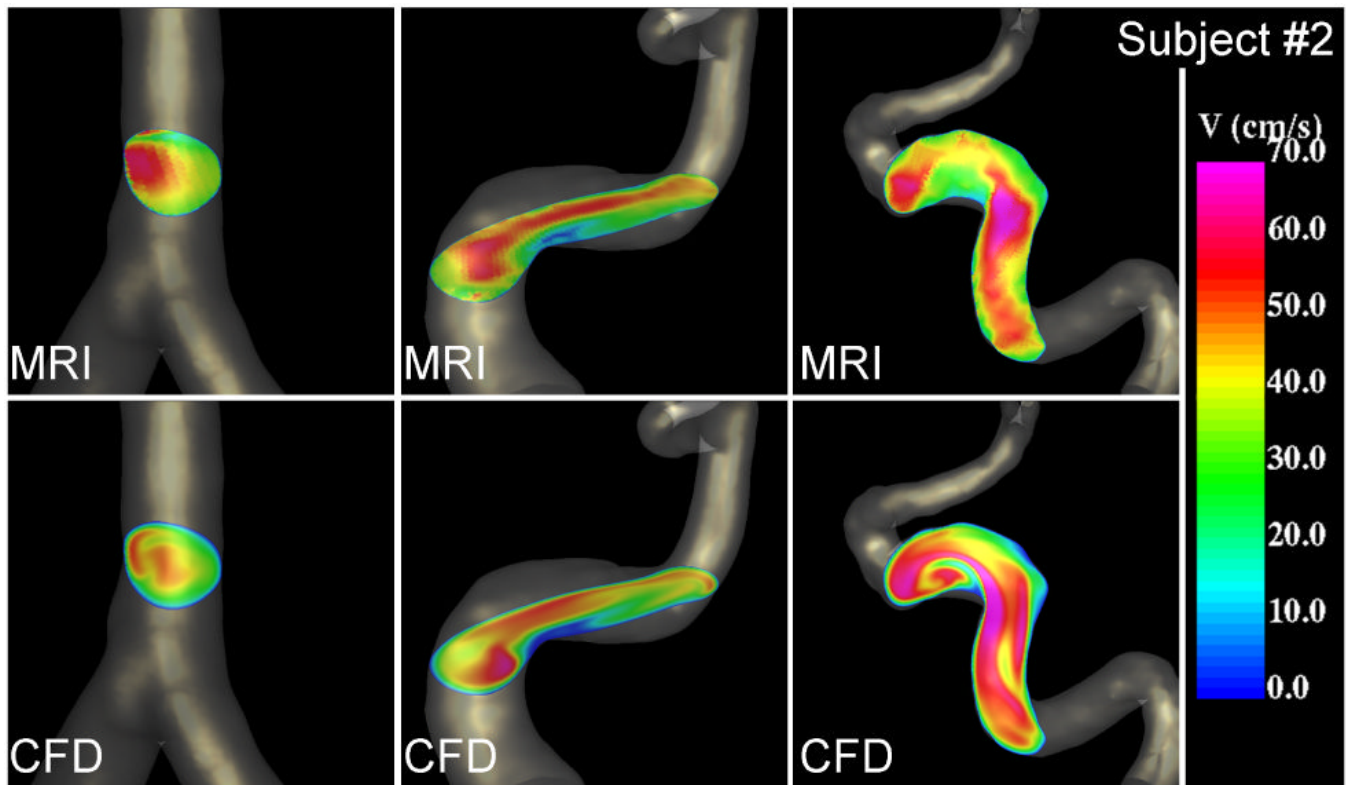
Velocity profiles at peak systole near the V-V junction (left), the right (center) and left (right) internal carotid arteries of subject #2 obtained from the MRI (phase-contrast MR) data and CFD model.
